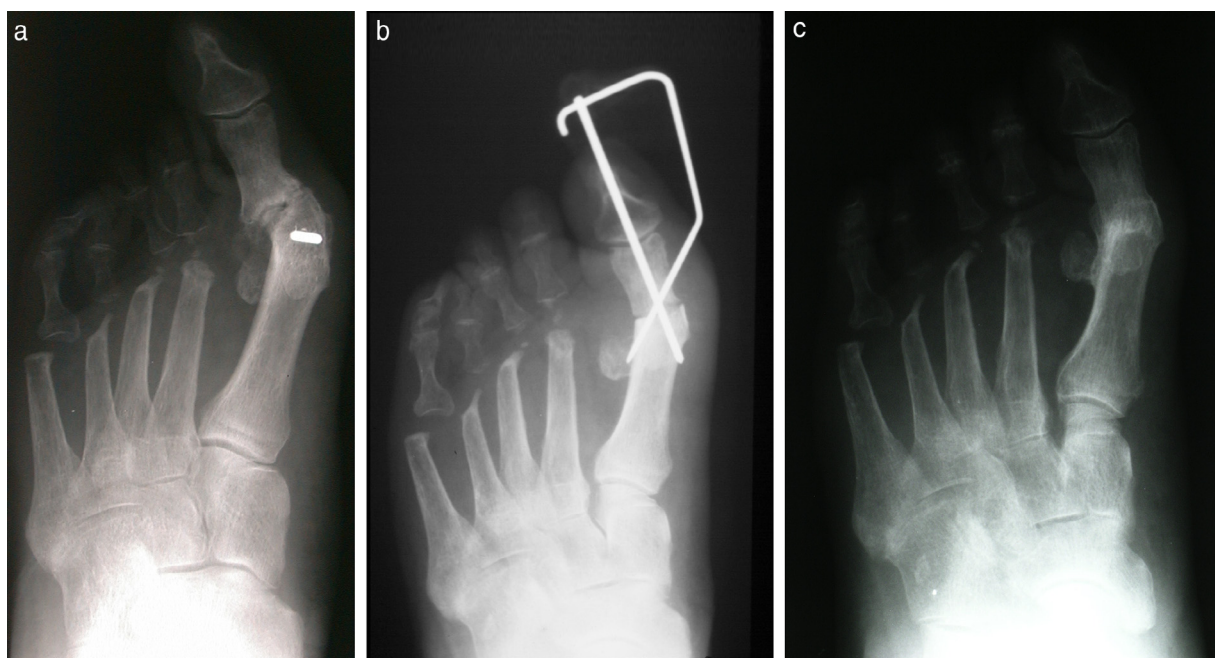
(a) This 80+ year old female had previously undergone removal of the lesser metatarsal heads and the proximal phalanges of the intermediate toes. A nonunion was also present at the 1st mpj. (b) Radiographic appearance following 1st mpj fusion. (c) 4.5 years postop.
